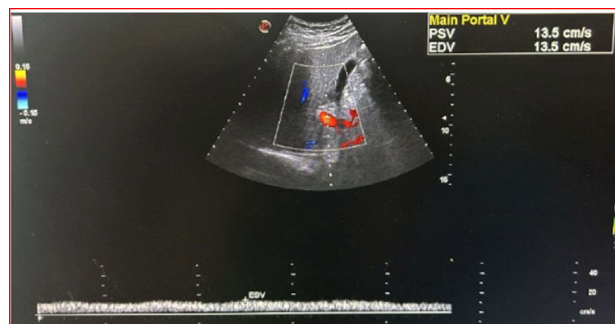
Color doppler ultrasound image showing reduced peak portal venous velocity (13.5 cm/sec) with reduced phasicity in a case of NAFLD.
